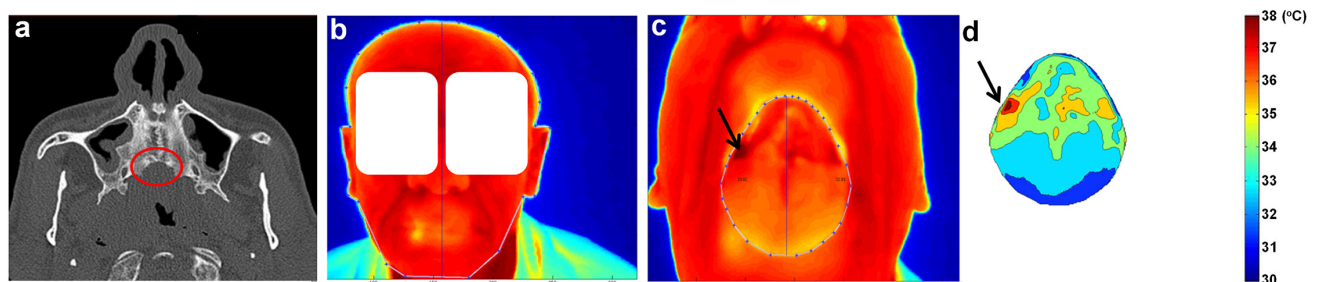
CT vs IRT images obtained in a 65-year-old male patient without visible facial deformity due to malignant tumour (SCC): on the axial CT image (a) vs frontal face TI (b) and open-mouth TIs before (c), and after segmentation (d), with the lesion region highlighted in dark colour (marked by arrow). Note: on the CT image (a) there is a hard palate bone destruction zone (marked by an ellipse). In the thermal image there is poor mouth's temperature asymmetry (c), but after segmentation (d) a clear zone with higher temperature is seen on the right side, with the lesion region highlighted in dark (marked by arrow). Other notations are same as in Figure 2. IRT, infrared thermography; TI, thermal image; SCC, squamous cell carcinoma.
